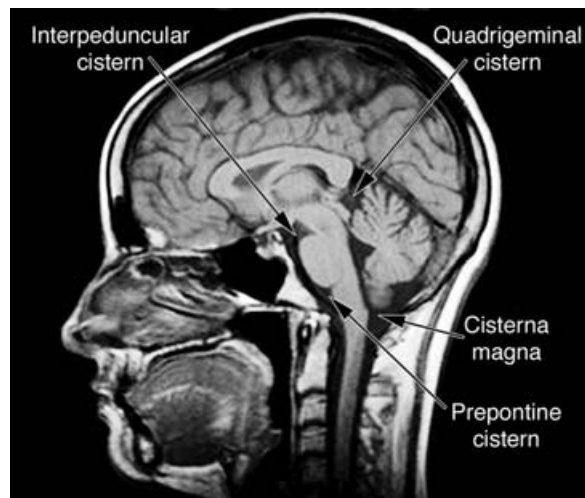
Major cisterns in a sagittal T1 MRI.
